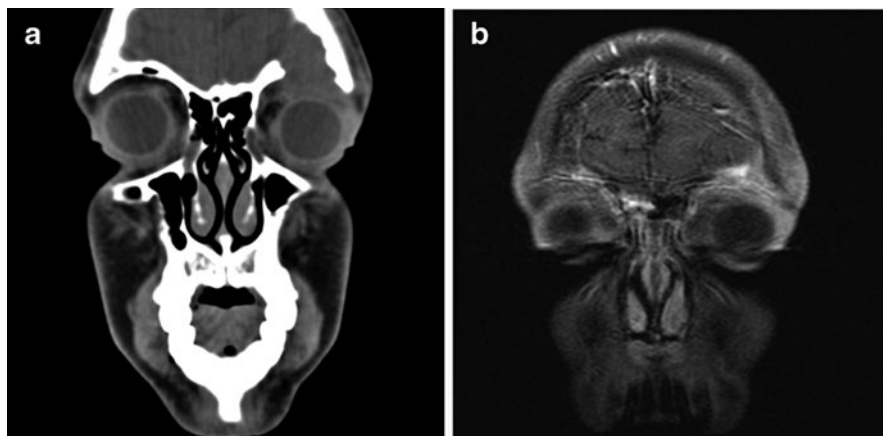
(a) Computed tomography of Langerhans cell histiocytosis of orbit with extension into the frontal lobe in a 12-year old. (b) There was significant resolution of the mass in the orbit with biopsy and curettage of the lesion through an anterior orbitotomy approach with injection of intralesional steroids
